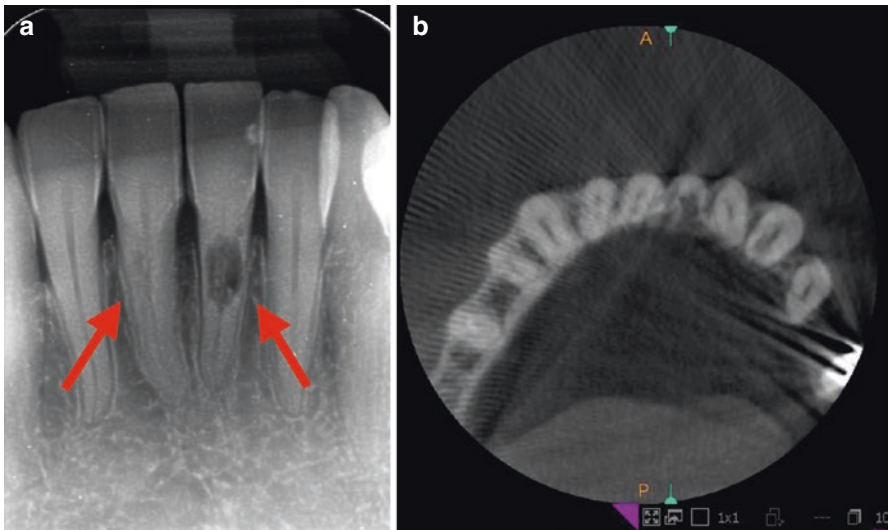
Radicular root resorptions of the central mandibular incisors are visible on the conventional 2D periapical radiograph (a). The CBCT helps clinician to know the extension of the resorption (class IV Heithersay) (b). In this clinical case, the left central incisor cannot be treated because of the extension of the resorption (class IV Heithersay)
